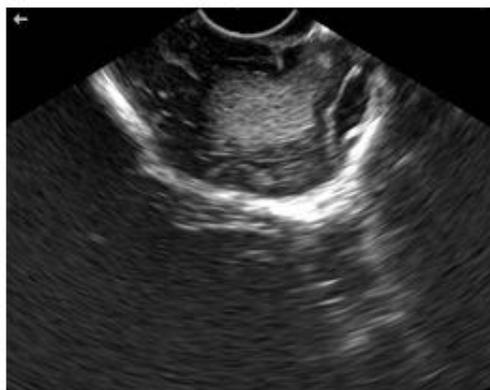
Intraoperative ultrasonography (resection monitoring with total excision)
